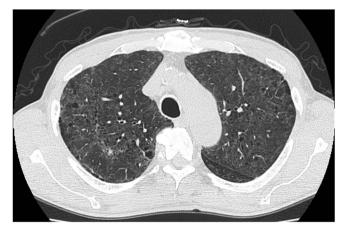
Chest CT showed a mosaic perfusion pattern and small nodules in the peripheral lung field.
